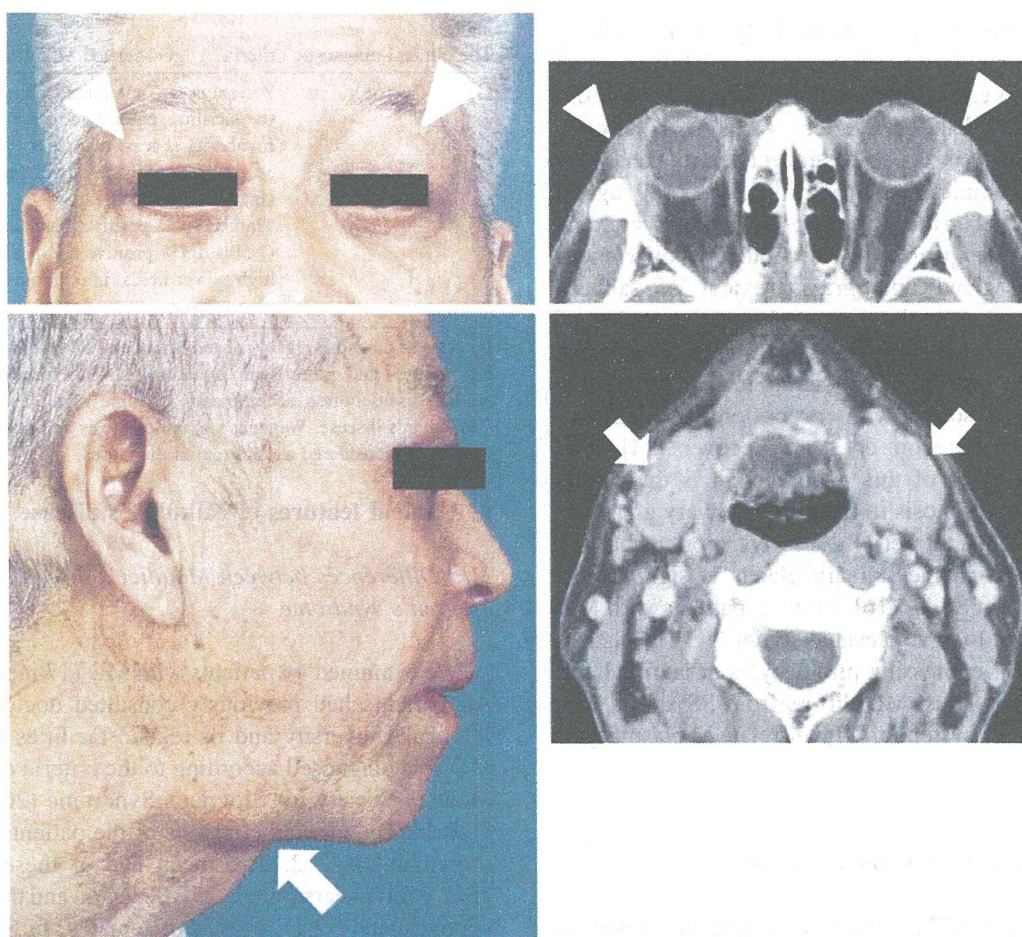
Facial views and computed tomography images of MD patients. The patients show persistent symmetrical enlargement of the lacrimal (arrow heads) and submandibular glands (arrows).
